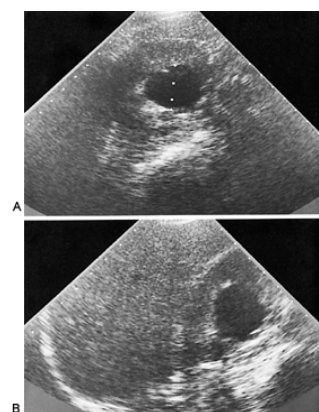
A-B: Simple cyst in 53-year-old woman. Renal ultrasonography reveals an anechoic renal mass with a smooth posterior wall and posterior wall enhancement.
